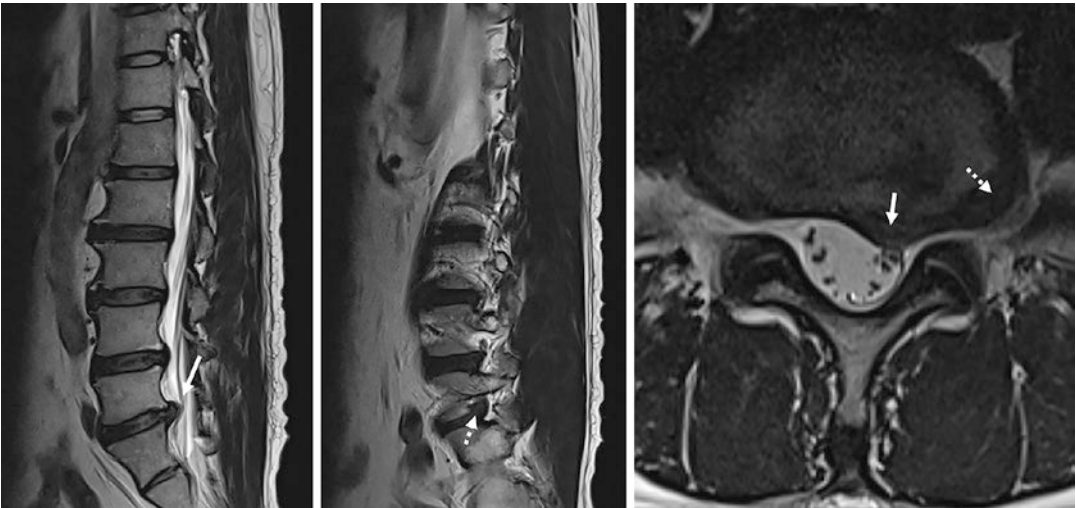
Pre-operative MRI images show para-central disc protrusion (white arrow) and extra-foraminal disc protrusion (white dot arrow) on L5-S1 level
